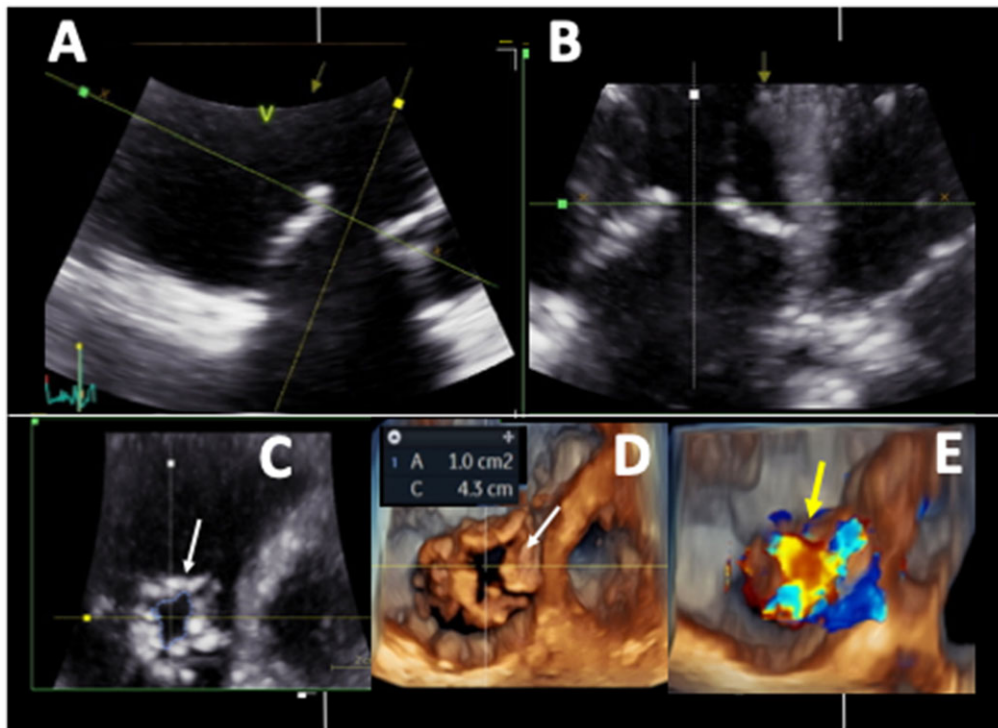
3D TTE acquisition in a patient with pulmonary hypertension and secondary TR. (A and B) Apical views showing the extent of leaflet tethering. (C and D) Quantitative assessment of the anatomic regurgitant orifice area using anatomically oriented cut planes to obtain and planimeter the true anatomical orifice area. (E) Size and shape of the VC obtained using 3D colour Doppler.
